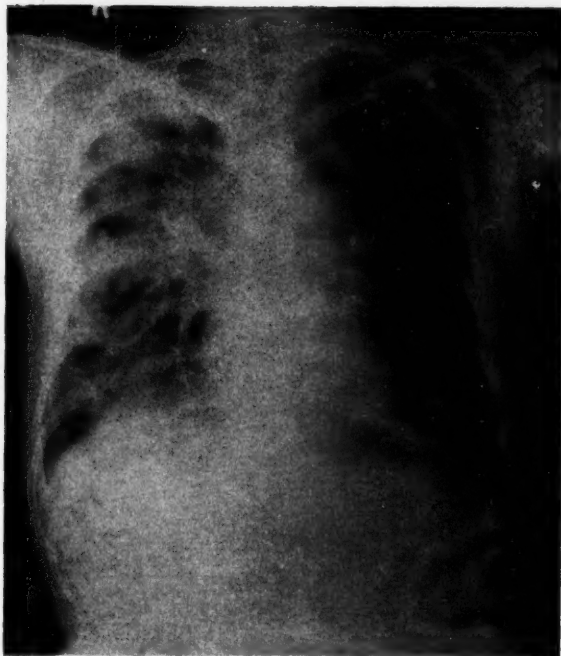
Chest roentgenogram April 19, 1947.
